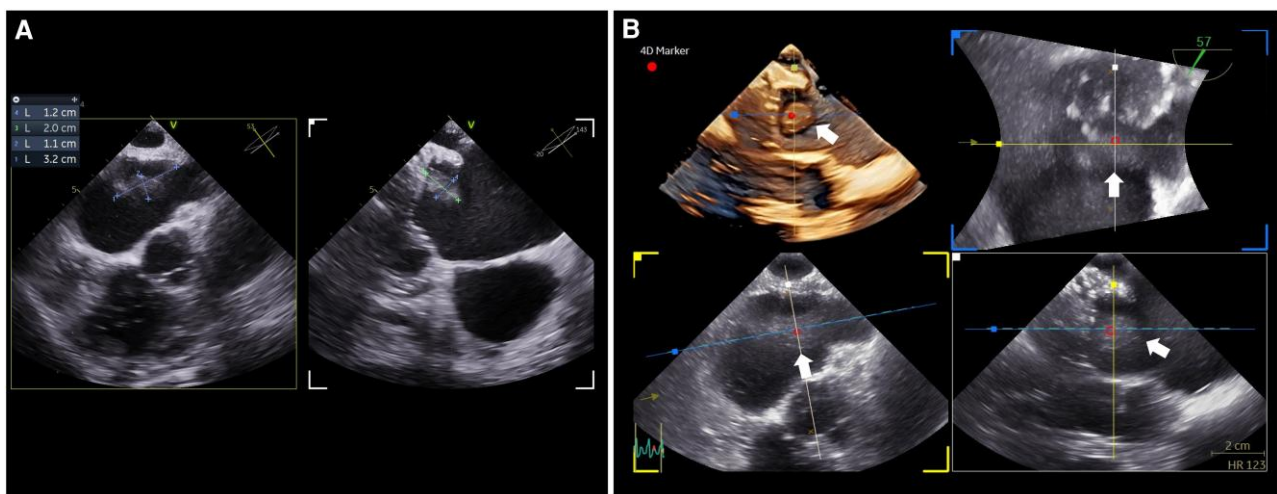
Transoesophageal echocardiography for the evaluation of an intracardiac thrombus. (A) Biplane views identifying an echogenic mass (1.2×2.0 and 1.1×3.2 cm in orthogonal planes) consistent with left atrial thrombus. (B) Three-dimensional multiplanar reconstruction image demonstrating the thrombus attachment site on the posterolateral wall of the left atrium near the left atrial appendage orifice; the precise location is confirmed by a 4D marker (white arrow).
